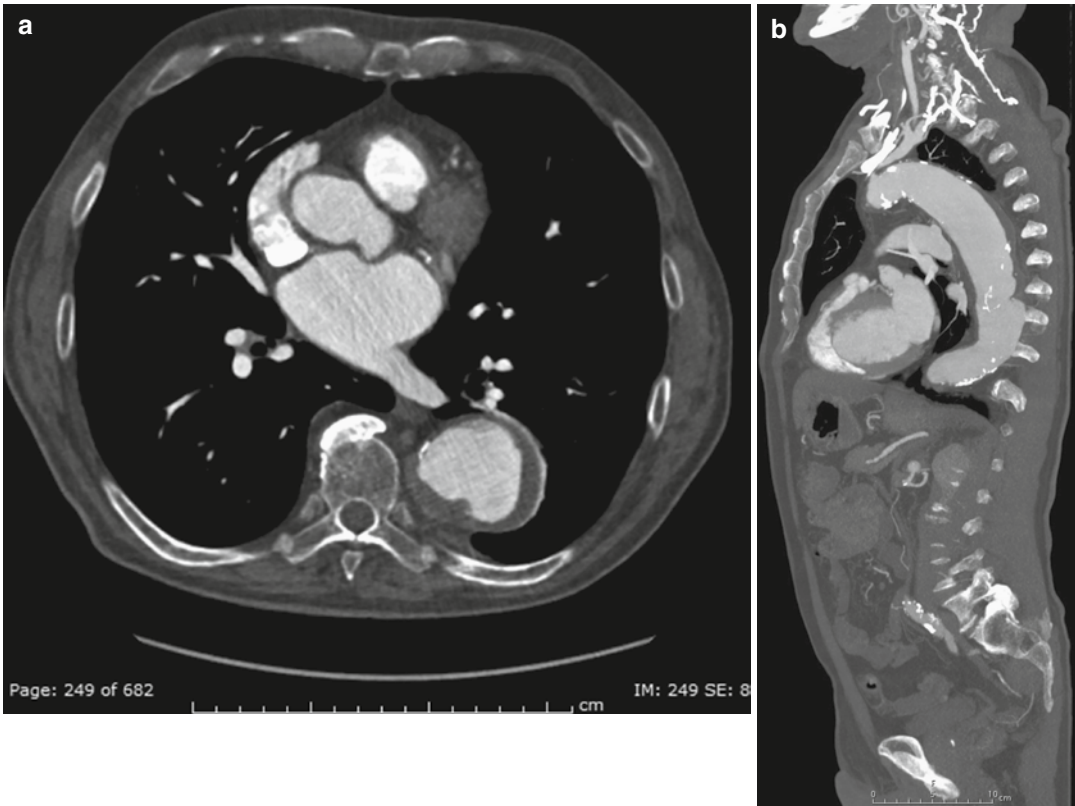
Descending TAA in an 82-year-old man. Contrast-enhanced (a) axial CT image shows an atherosclerotic aorta, with fusiform aneurysm. (b) Sagittal MIP image shows the overall extent of the aneurysm in the descending aorta
